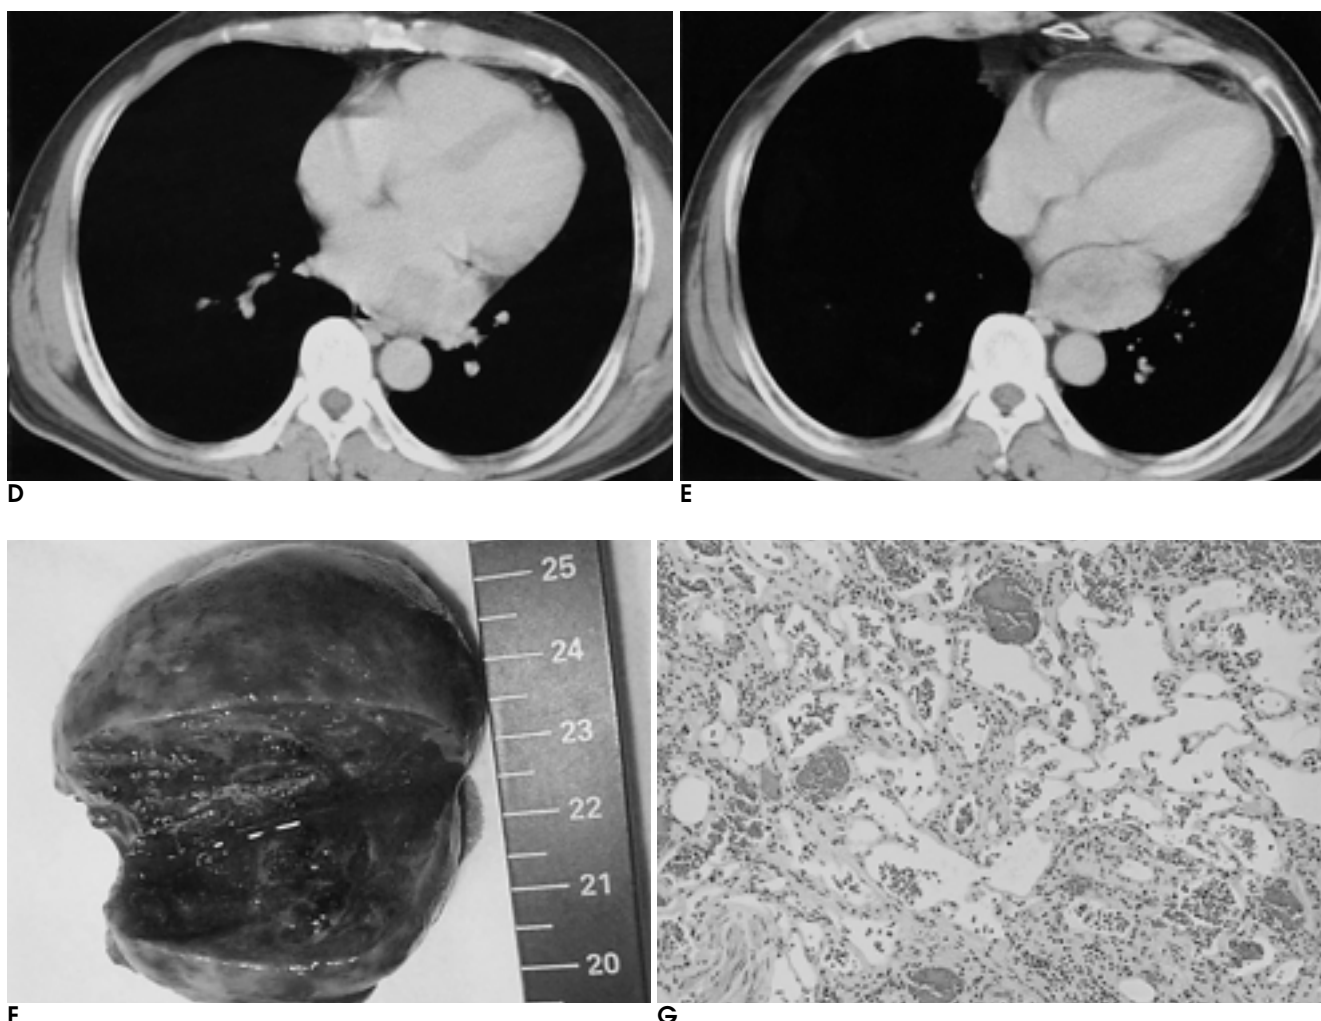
D, E. Delayed phase CT images show a well-demarcated mass with dense peripheral enhancement.
